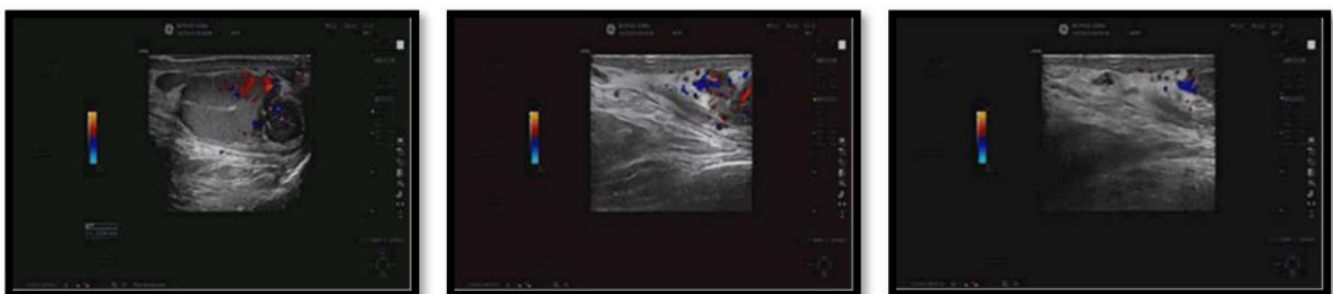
Ultrasound results showing left epididymal tail inflammation and spermatic cord involvement.
